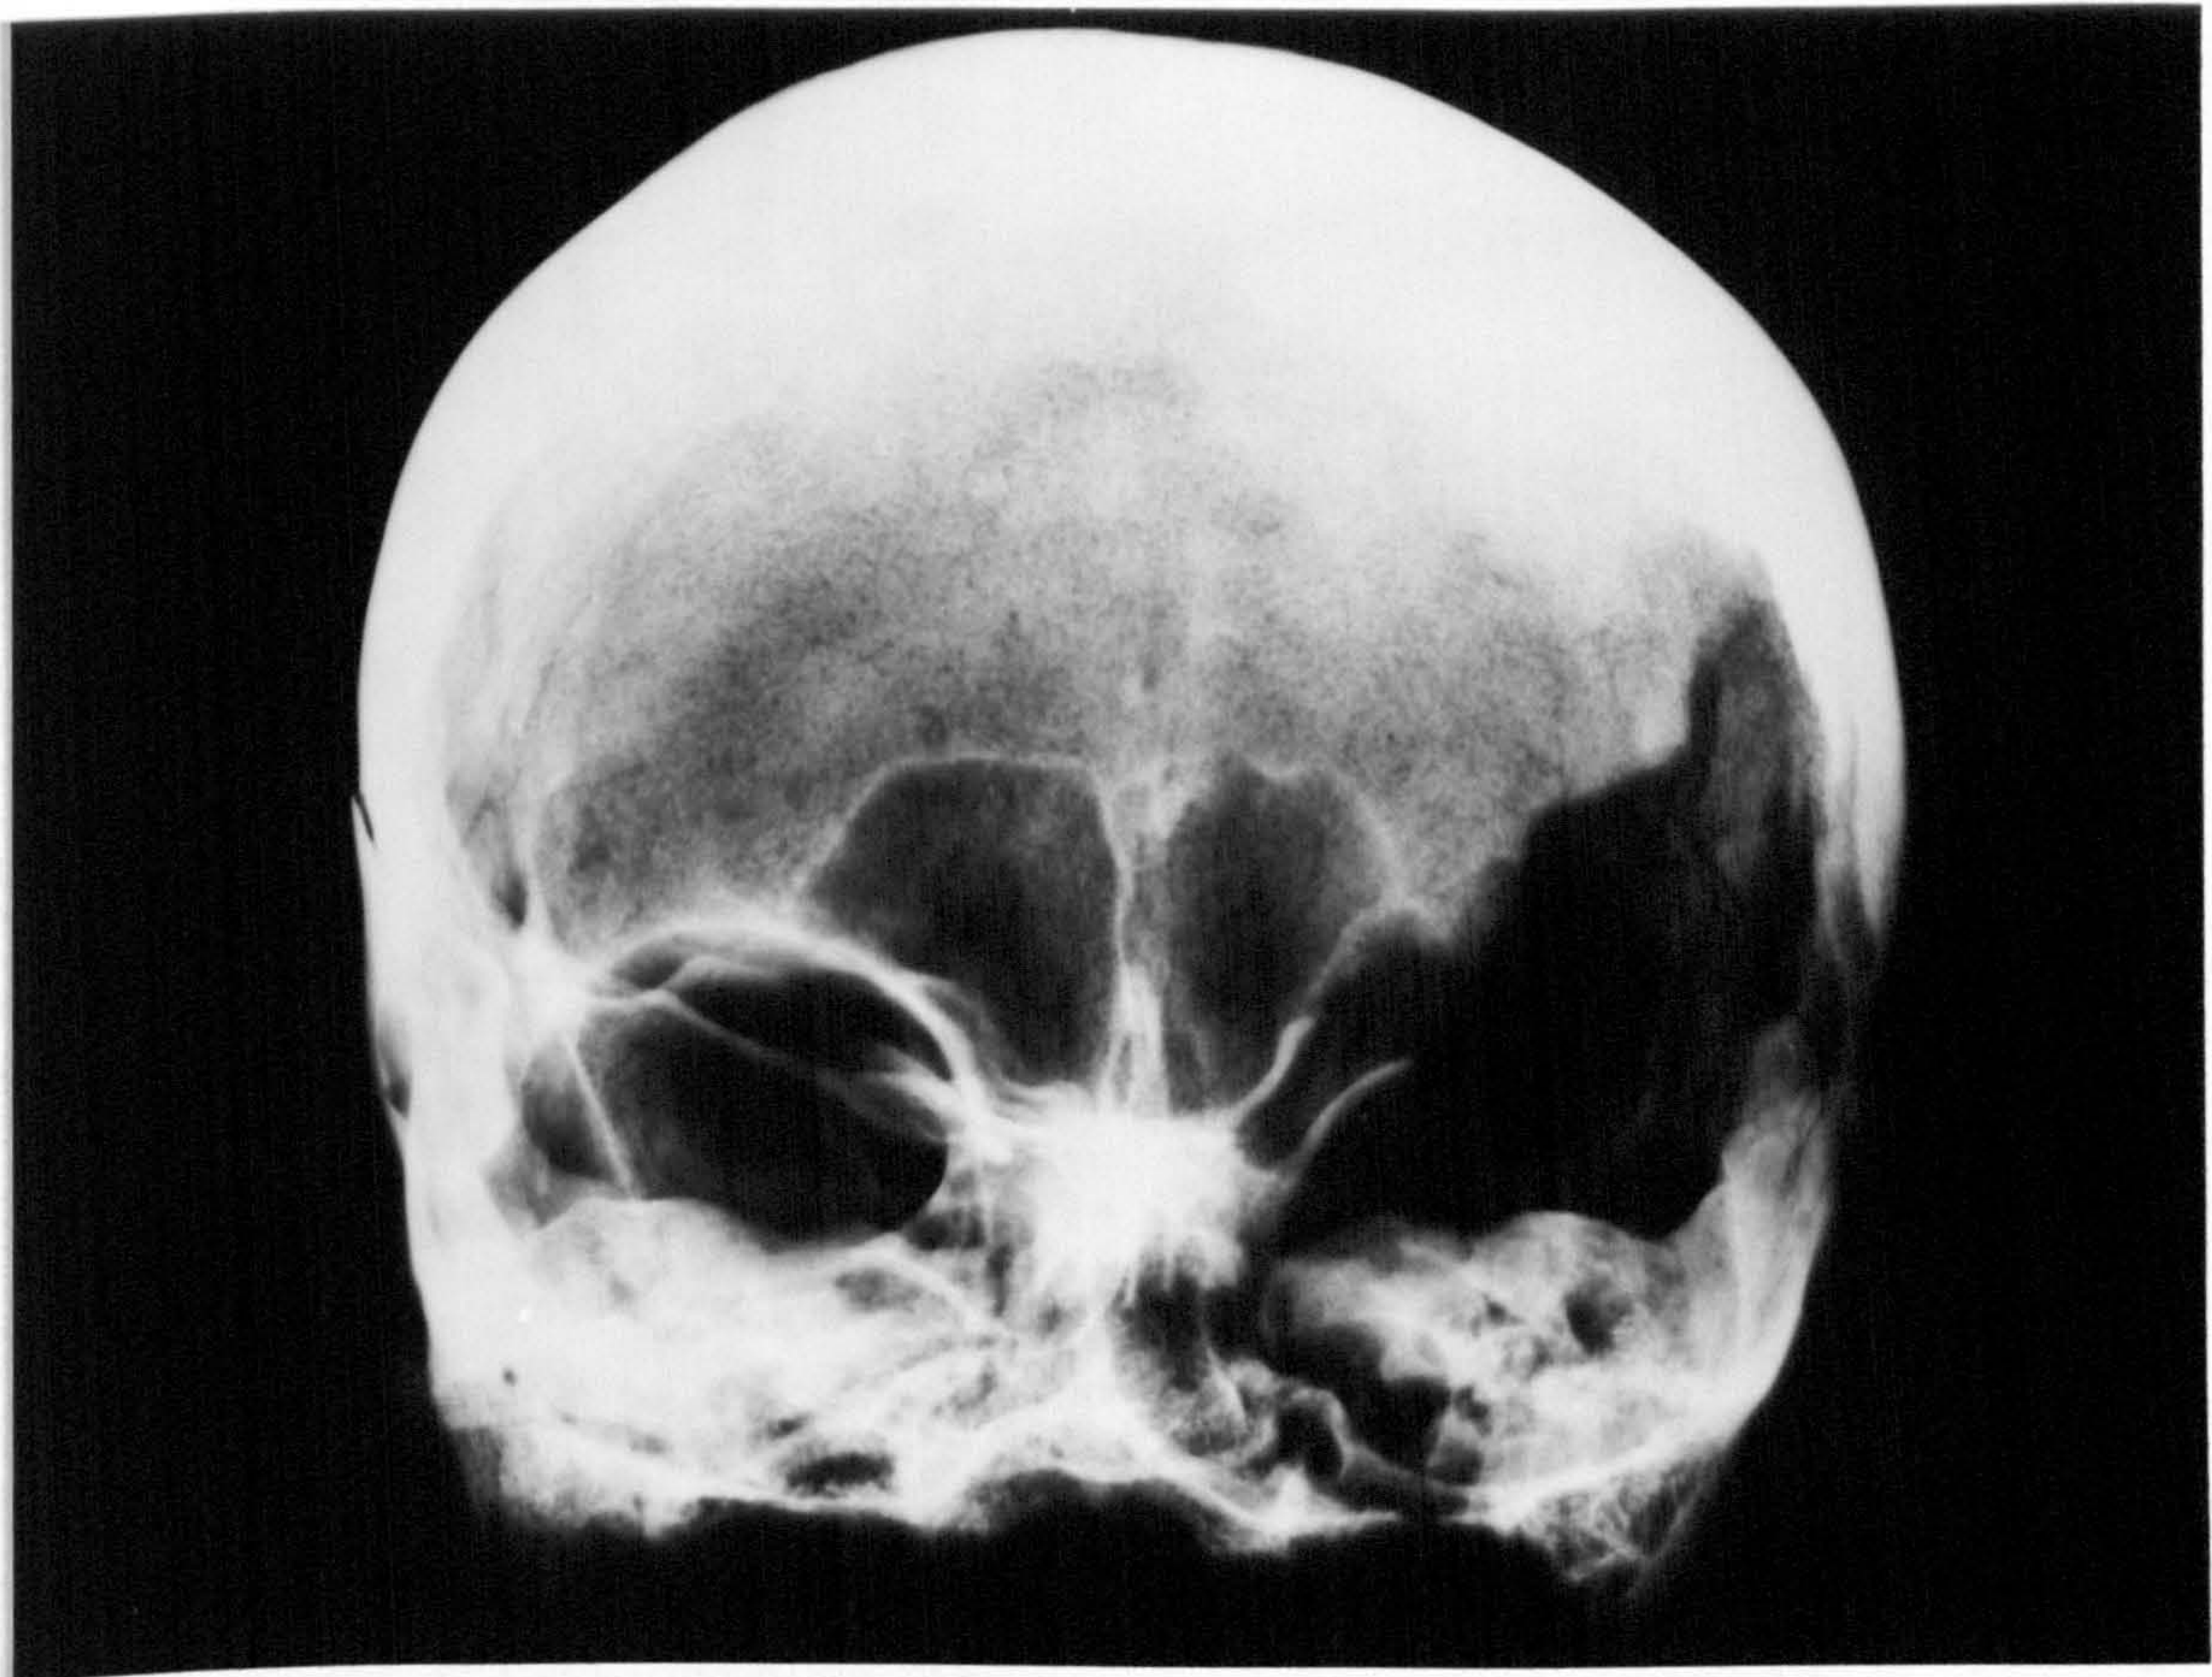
X-ray appearance of sk 547
